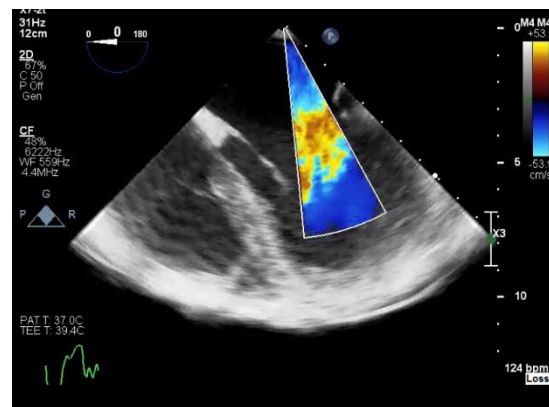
Transoesophageal echocardiogram demonstrating mitral regurgitation with an eccentric jet.
